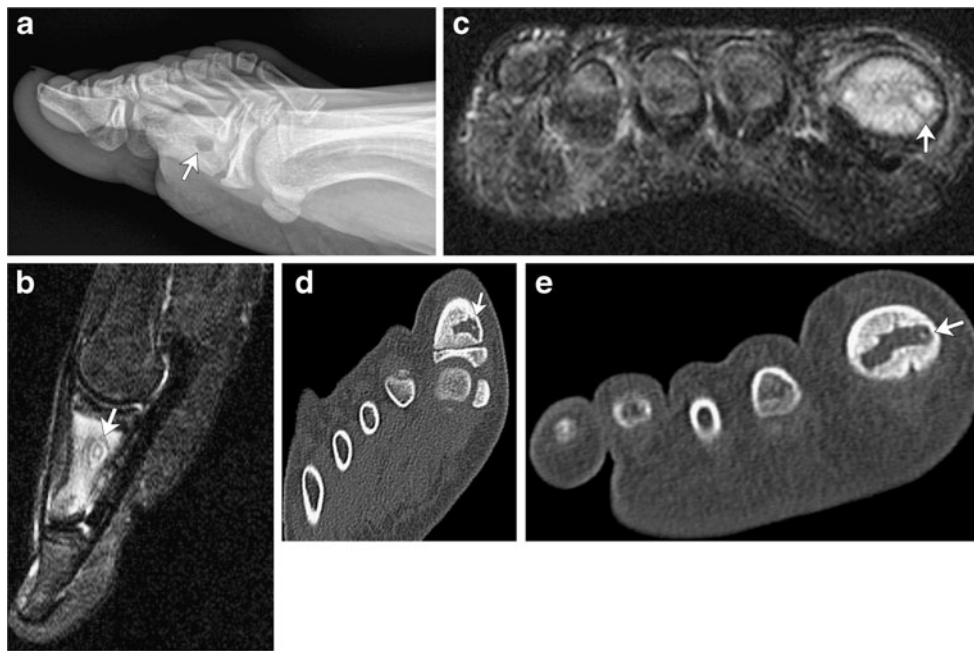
An 8-year-old boy with great toe pain. a Lateral radiograph of the foot shows a circumscribed lucency in the proximal aspect of the first proximal phalanx (arrow) without surrounding sclerosis. Sagittal STIR (b) and short-axis axial fat-saturated T2-weighted (c) MR images demonstrate a rounded T2 hyperintense lesion with hypointense rim (arrows) thought to represent a nidus of an osteoid osteoma with surrounding sclerosis. Note high T2 signal of the remainder marrow
